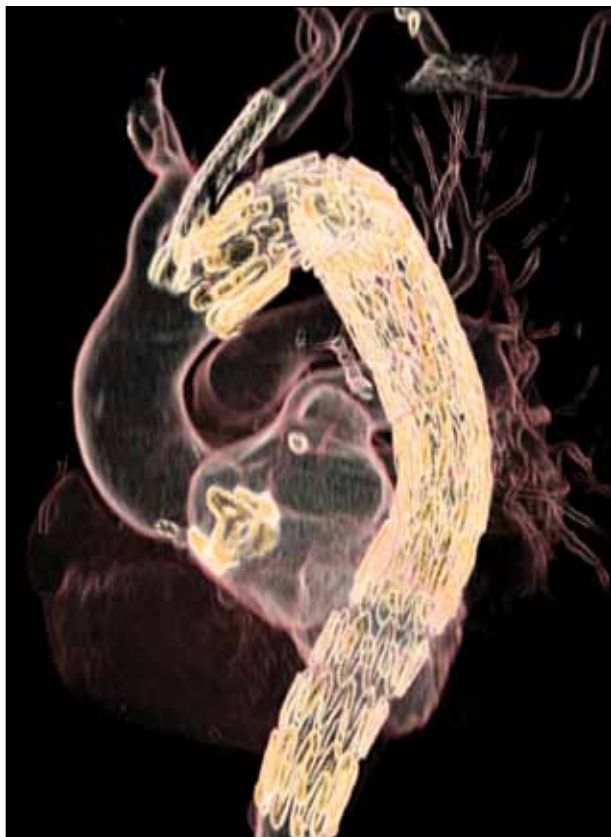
Postoperative computed tomography maximum-intensity projection image shows the correct position of the iCast stent in the left common carotid artery and the Zenith TX2 aortic endoprostheses.
